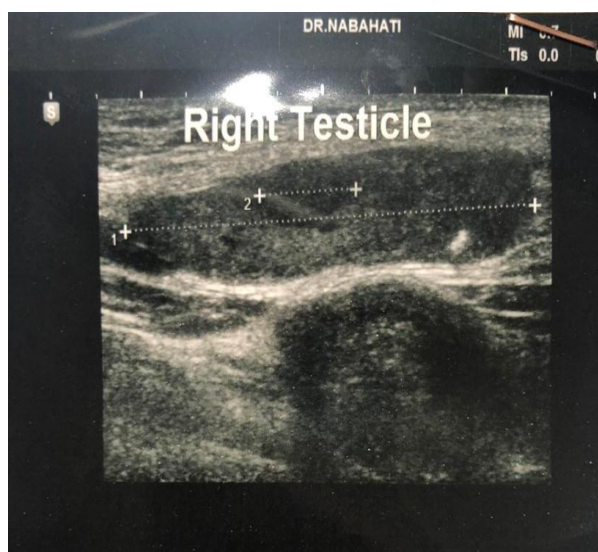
Ultrasound view of right testicular tumor
